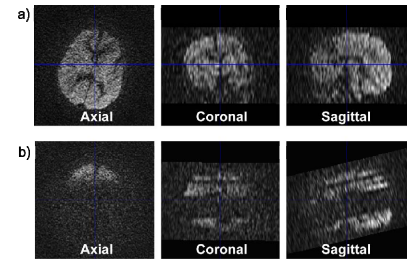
GRAPPA R=3 DWI (one direction, no averaging) on patient A post image realignment. a) DWI volume with no intra-volume motion. b) DWI volume with intra-volume motion, leading to erroneous 3D image realignment
